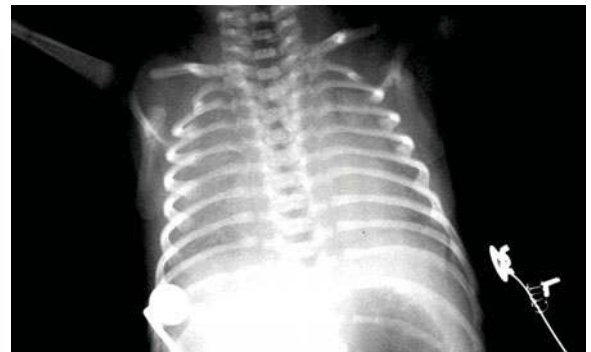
Newborn infant born at 35 weeks of gestation to a mother treated during a previous pregnancy for congenital syphilis. The radiograph demonstrates a diffuse and bilateral pneumonitis, and the child had clinical findings of pneumonia. Associated bone changes are barely visible in the humeri, but are more apparent on other bone films. The infant responded well to appropriate antibiotics
